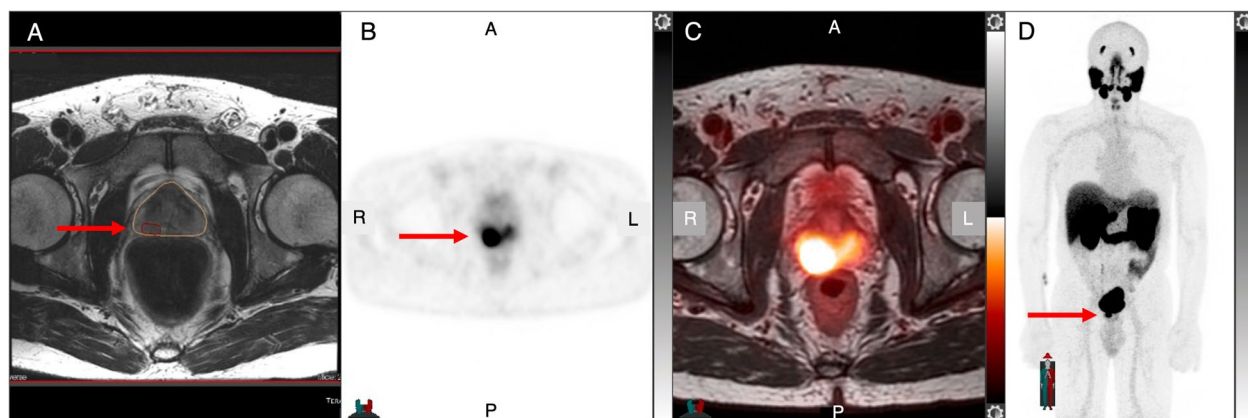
48-year-old man presents with PSA 11.30 ng/mL and PSA density 0.31 ng/mL² for targeted prostate biopsy: mpMRI A shows a PI-RADS 4 lesion in the right lateral base whereas ⁶⁸Ga-PSMA11 axial PET B, axial fused PET/MRI C, and maximum intensity projection (MIP) D reveal a larger tumor volume. Subsequent PET-targeted biopsy resulted in a Gleason score 4 + 3 prostate cancer
